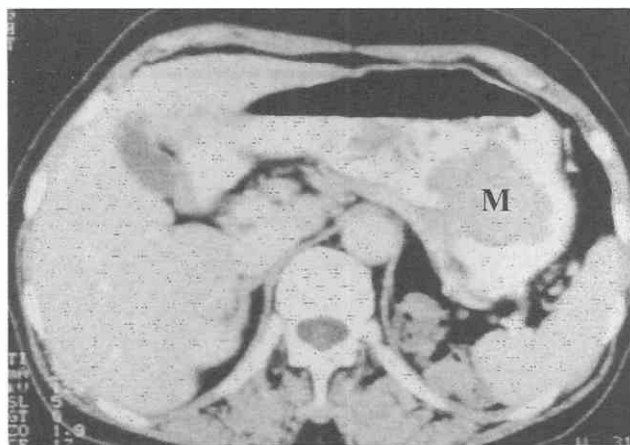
Gastric adenoma with malignant transformation. CT scan shows a polypoid mass (M) with a short, thick stalk.
